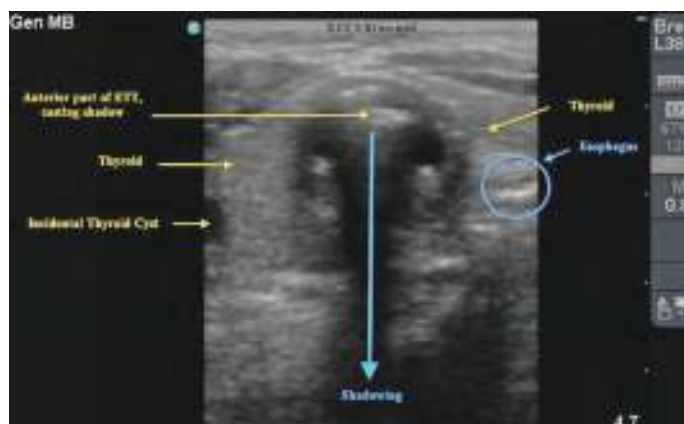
US image of an ET intubation with the transducer placed horizontally just above the sternal notch. (Photo courtesy of Ultrasound Section, Emory University Department of Emergency Medicine.)
